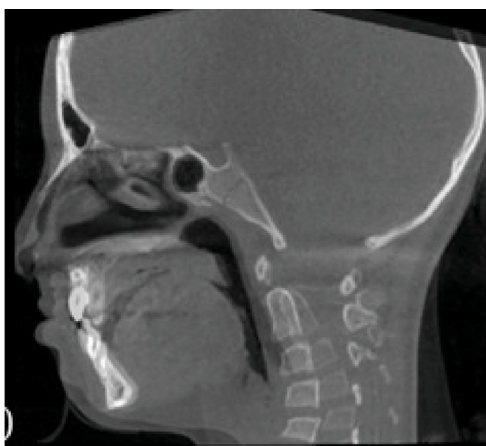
Cone beam computed tomography superimposition.
